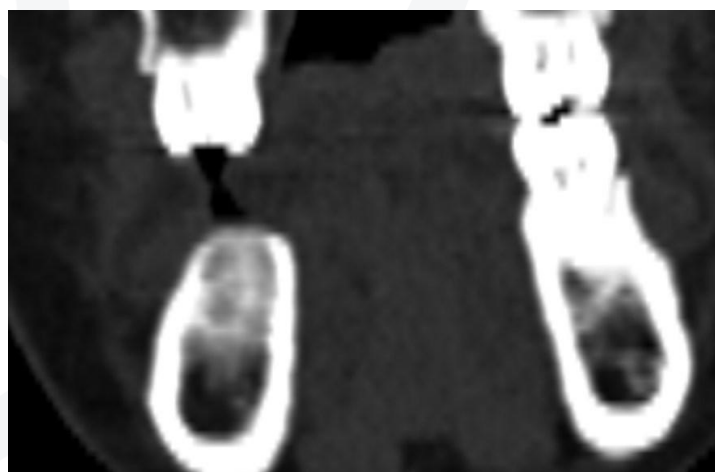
CT scan in projection 36 bone density is D4, loose spongy substance.
